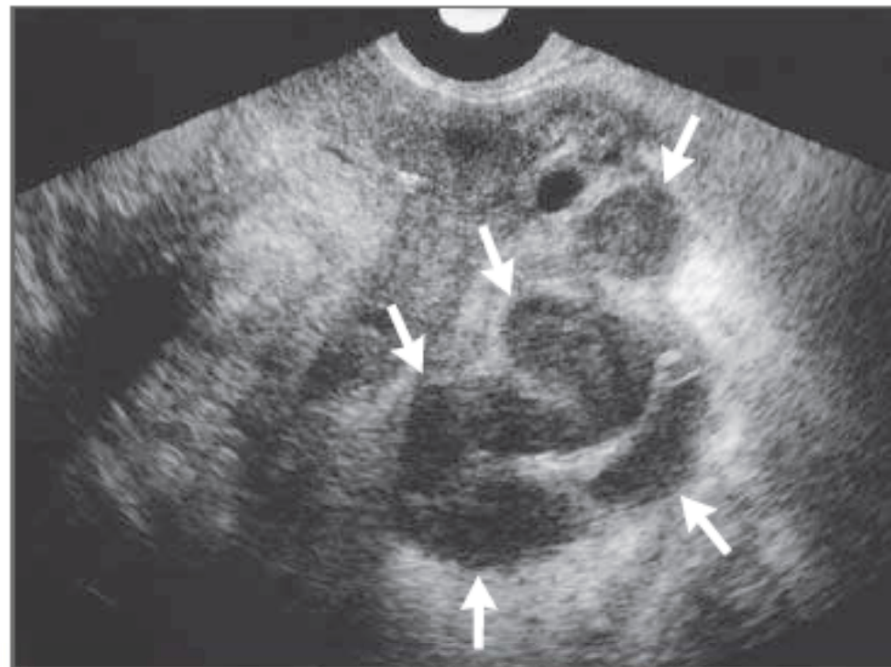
Endovaginal Ultrasonogram in a 46-Year-Old Premenopausal Woman with Right-Lower-Quadrant Pain, Adnexal Tenderness, and an Elevated White-Cell Count.
